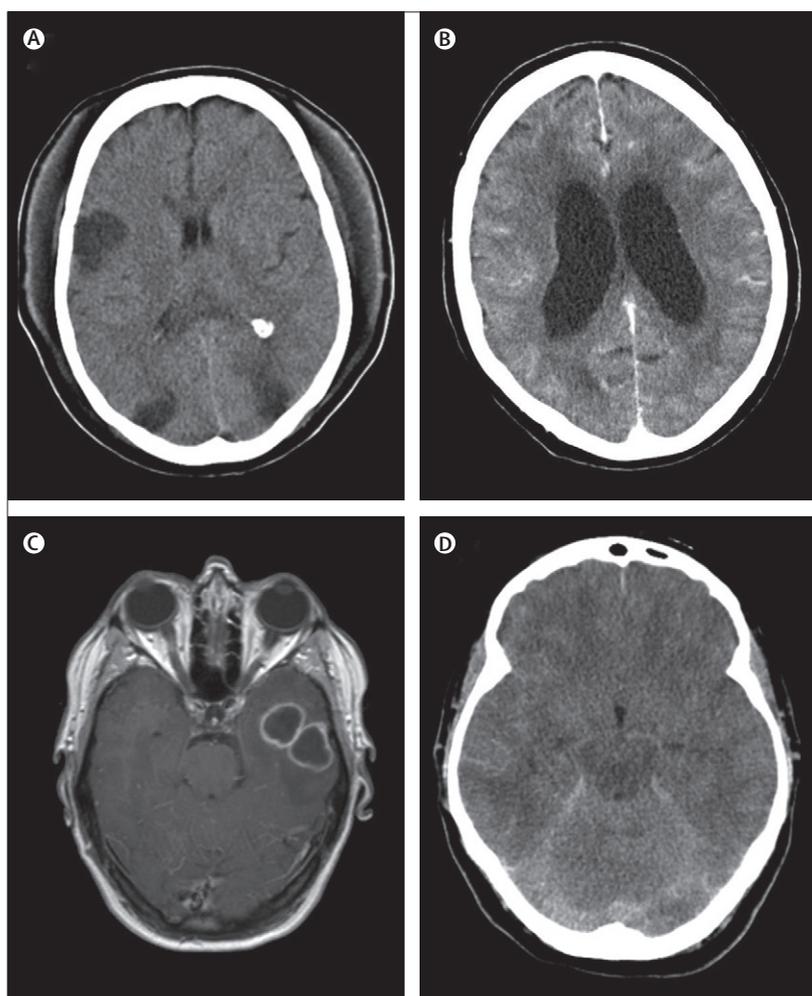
Cranial CT findings in patients with bacterial meningitis that potentially contraindicate a lumbar puncture
